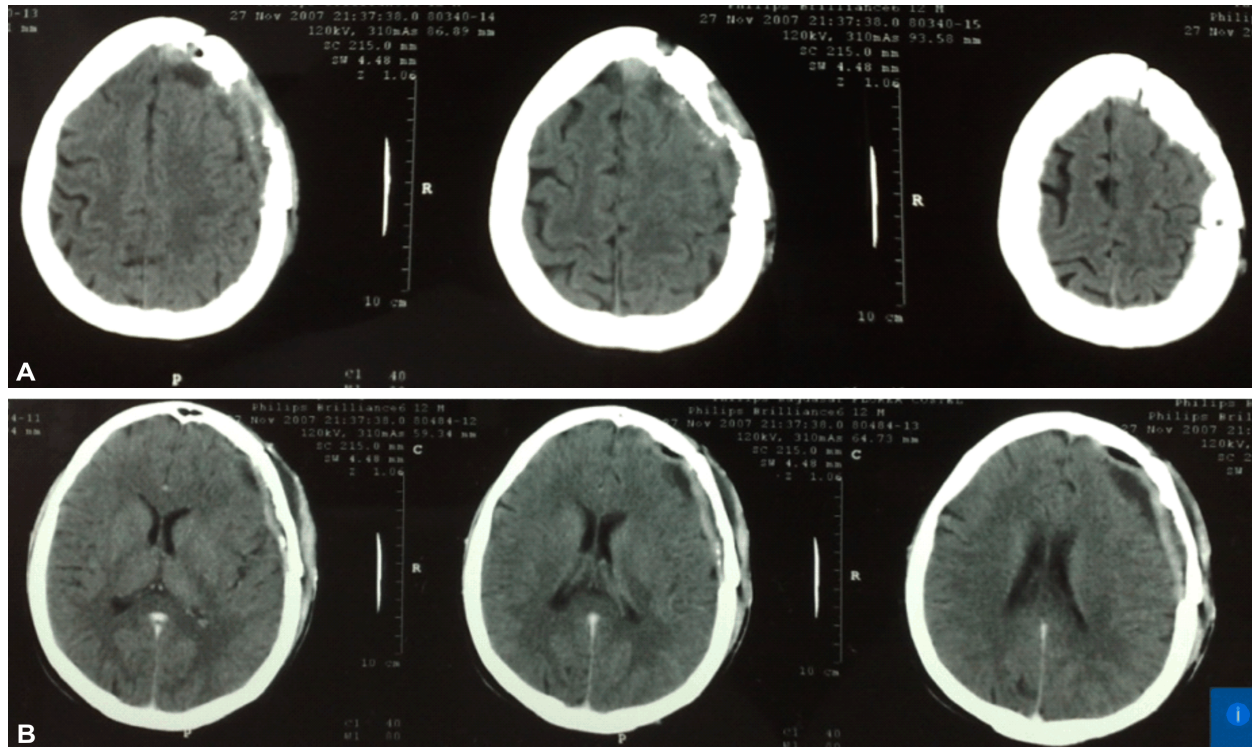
(A and B) The final postoperative CT scan shows no tumor fragments remaining, with midline structures in place and a physiological ventricular system.
